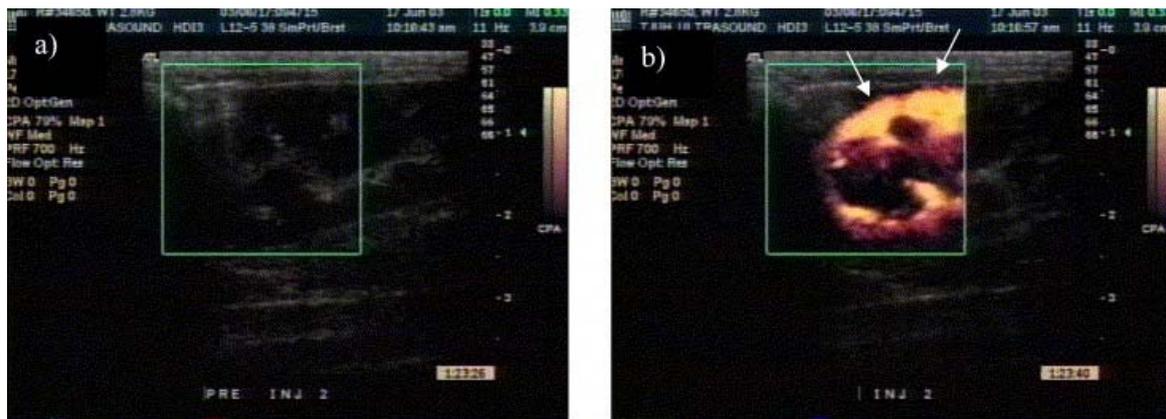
Power Doppler image of New Zealand rabbit right kidney, (a) preinjection; (b) postinjection of 0.1 mL/kg of ST68-N (3 min at 300 RPM). Arrows indicate kidney capsule. Copyrighted from reference²
